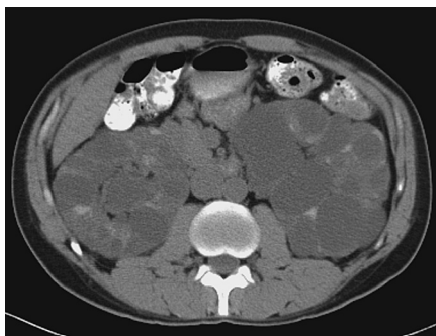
This noncontrast computed tomography (CT) image demonstrates autosomal dominant polycystic kidney disease. The kidneys are markedly enlarged bilaterally with multiple low-density cysts throughout both kidneys. The little remaining renal parenchyma is noted by the sparse higher density material squeezed by the cysts. (From Brenner B. Brenner and Rector's the kidney, 8th ed. Philadelphia: Saunders, 2008, Fig. 27-30.)
